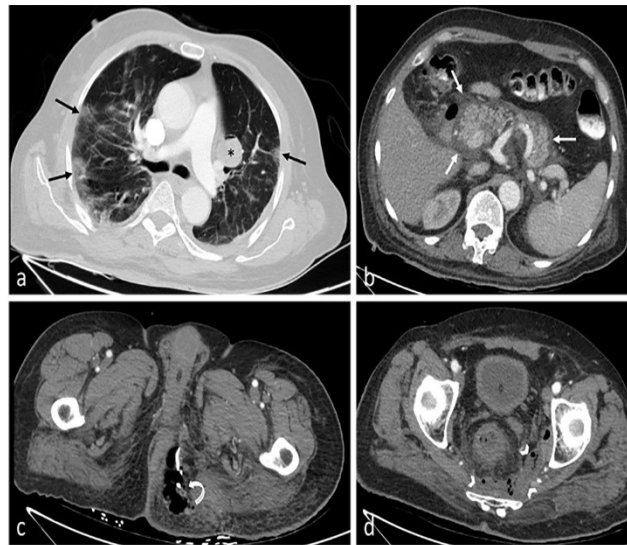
Acute pancreatitis and Fournier's gangrene in a 63-year-old man with COVID-19 pneumonia. Axial chest CT (a) shows multifocal subpleural patchy areas of ground glass opacity (black arrows). Also, a thin-walled cavitory lesion is seen (black asterisk). Axial contrast-enhanced CT (b) reveals an enlarged pancreas with surrounding fat stranding and inflammatory changes (white arrows) in keeping with acute pancreatitis. Axial CT images (c, d) demonstrate left perineal soft tissue gas (curved arrow) associated with abscess formation in the presacral region (arrowheads) secondary to Fournier's gangrene.
